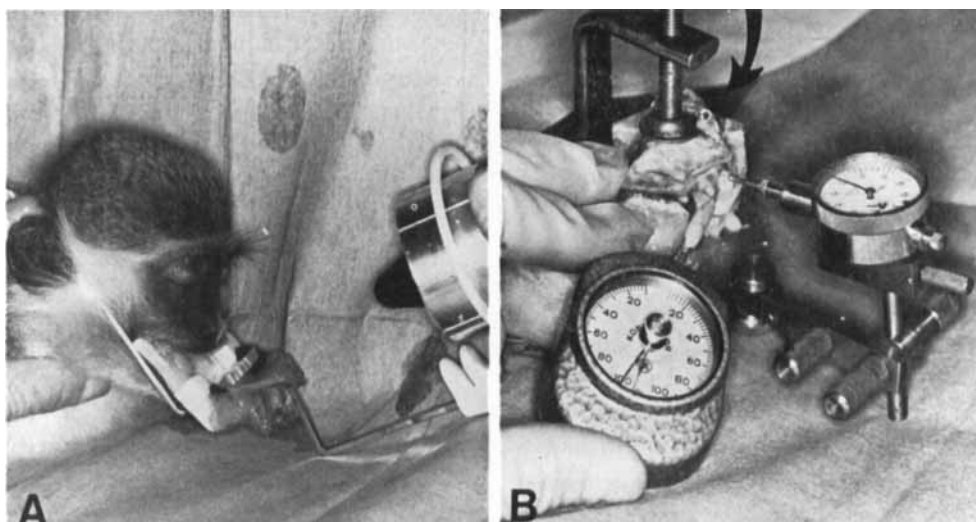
A. Filmholder used for radiographic examination of replanted incisors. B. Clamp system used for fixation of anterior jaw segment during mobility testing of replanted incisors (arrow).
